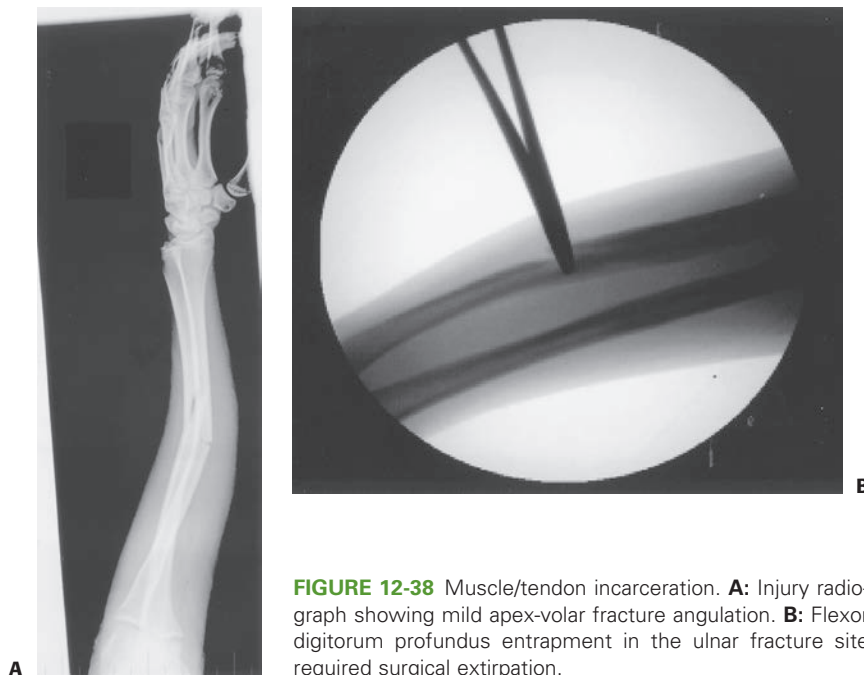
Muscle/tendon incarceration. A: Injury radiograph showing mild apex-volar fracture angulation. B: Flexor digitorum profundus entrapment in the ulnar fracture site required surgical extirpation.
